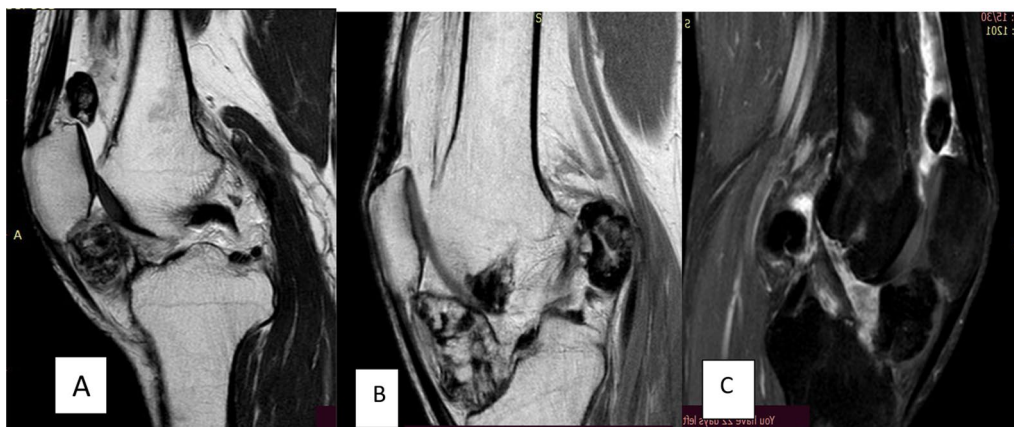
A–C Magnetic resonance imaging finding of the patient
